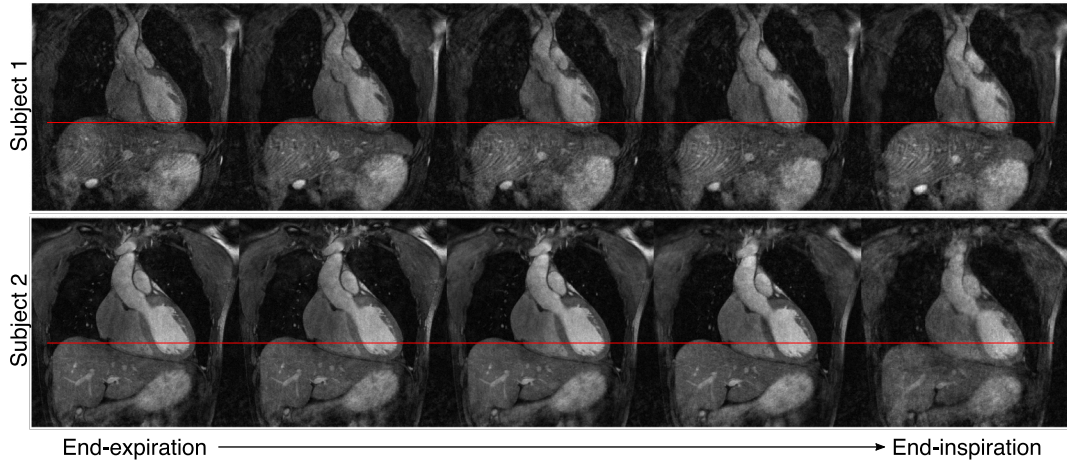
Reconstructed MR images at five respiratory positions (bins) for two representative healthy subjects. A red line drawn at the level of the diaphragm in end-inspiration is included for reference purposes. Despite residual undersampling artefacts, the respiratory bins allow for estimation of non-rigid motion fields.
